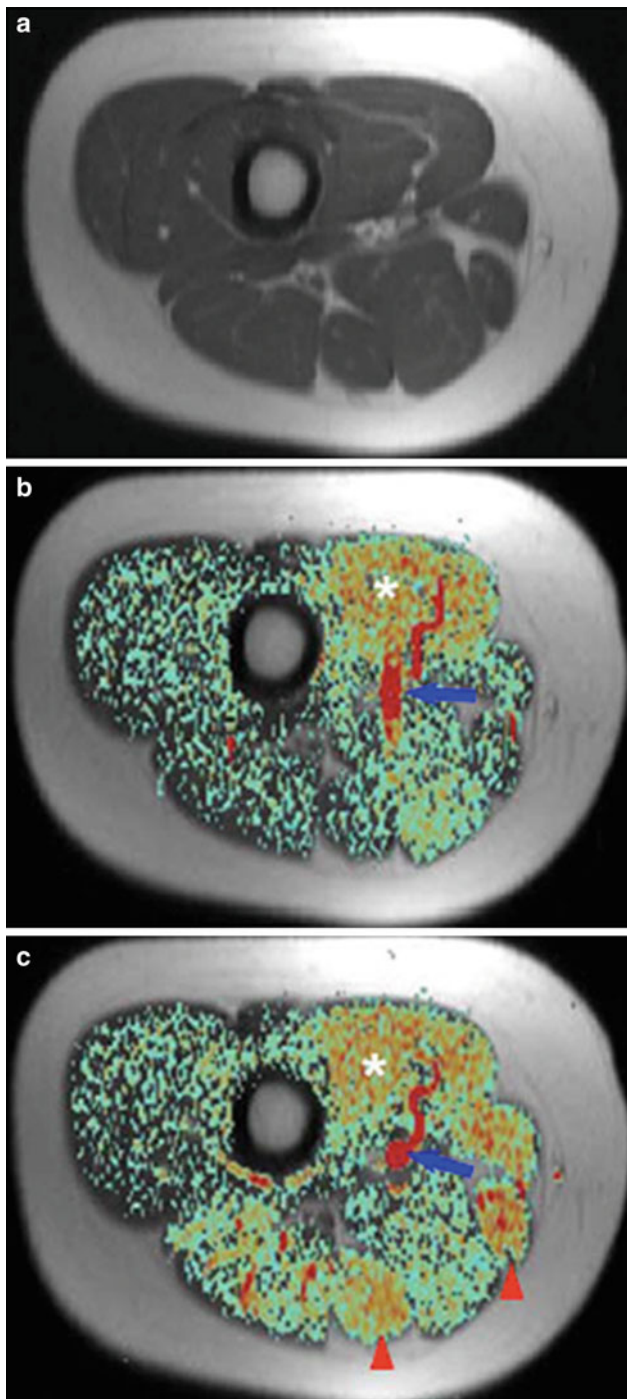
Anatomic T1-weighted image (a) and color-coded perfusion weighted ASL image (b) of the right mid-thigh of a 24-year-old woman at rest on a 1.5-T whole body scanner (PICORE tagging scheme, 10-mm slice thickness, $TR = 3,500$ ms, $TE = 30$ ms, inflow time $TI = 600$ ms, 256–128 matrix, 25 averages, acquisition time $TA = 3$ min). After knee flexion exercise against a 3-kg weight for 5 min significant hyper-perfusion in all thigh-flexor muscles can be observed (arrowheads), while the adductor muscles (asterisk) already have elevated perfusion at rest—resulting from a preceding exercise test (c). The blue arrow indicates the femoral vessels, which have the highest signal on ASL images. As expected, no perfusion signal appears in bones and subcutaneous fat tissue. From Weber et al. (2007). This material is reproduced with permission of Springer
